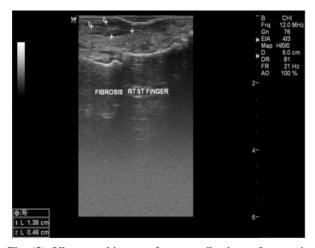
Ultrasound image of severe adhesions after repair using modified Kessler repair in Zone II.
